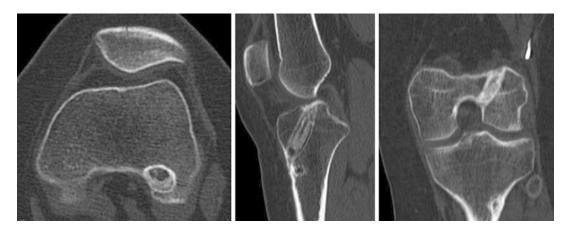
CT revealed ACL tunnel widening of >14 mm
